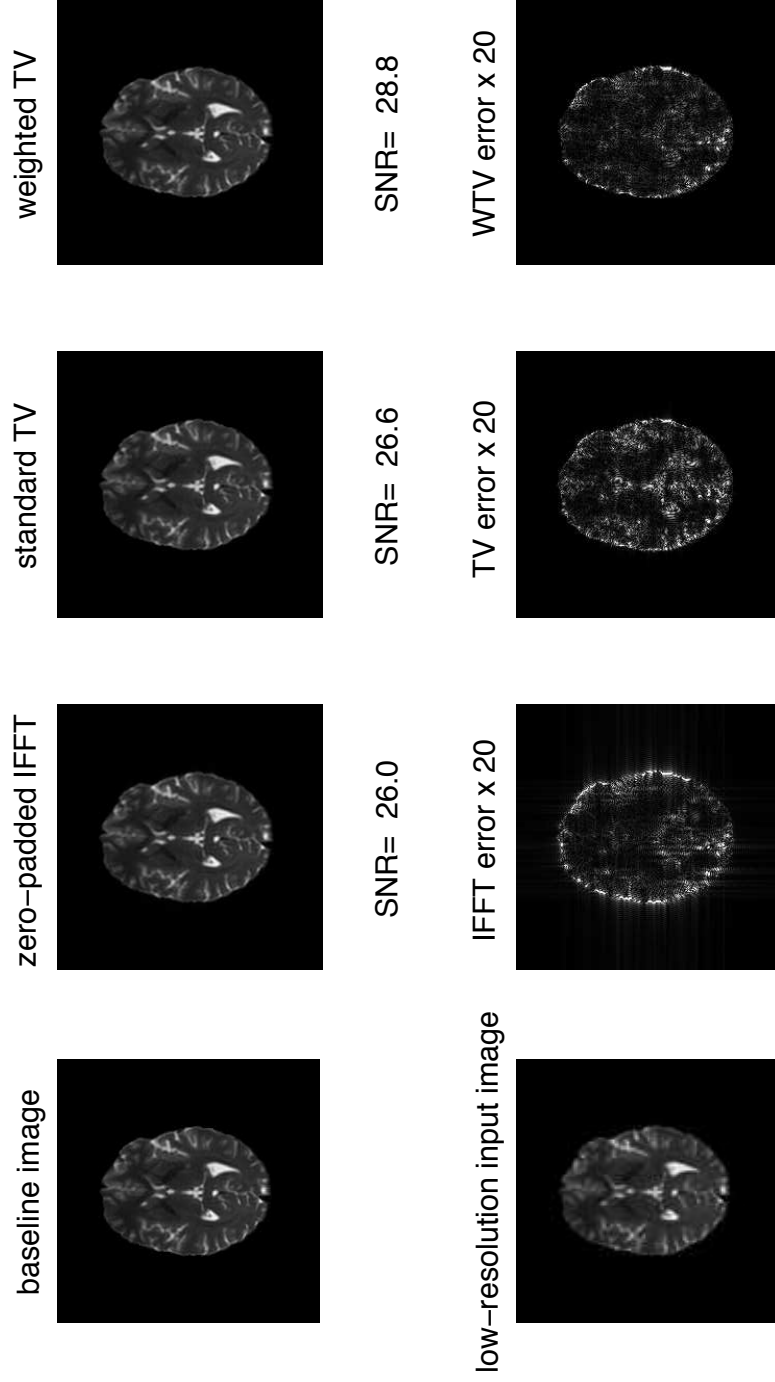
Reconstructed b_0 component of a typical DWI subject using 3 different methods. The SNR value is provided for the result of each method demonstrated in the first row. The second row shows the low-resolution image, by a factor of 2, and the difference image between each reconstructed image and the original high-resolution baseline image, that is magnified by 20 times. The higher SNR value for the developed weighted-TV approach indicates better reconstruction results.
